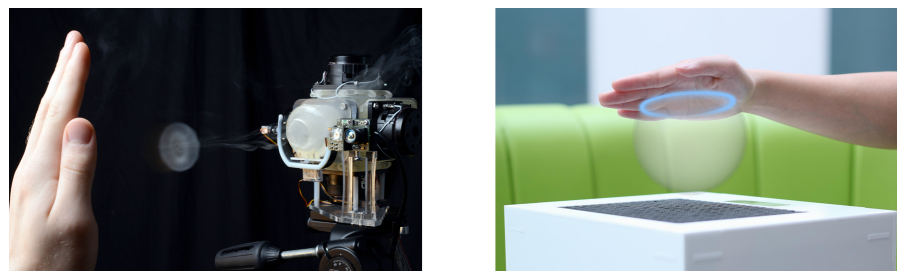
Invisible haptics. Left: *AIREAL* emits vortices that users can feel mid-air. (Source: extracted and cropped from Sodhi et al. [316]; ©2013 ACM). Right: *UltraHaptics* emits ultrasound to the user's palm, producing tactile haptics. (Source: extracted from Long et al. [223]; ©2014 ACM).
